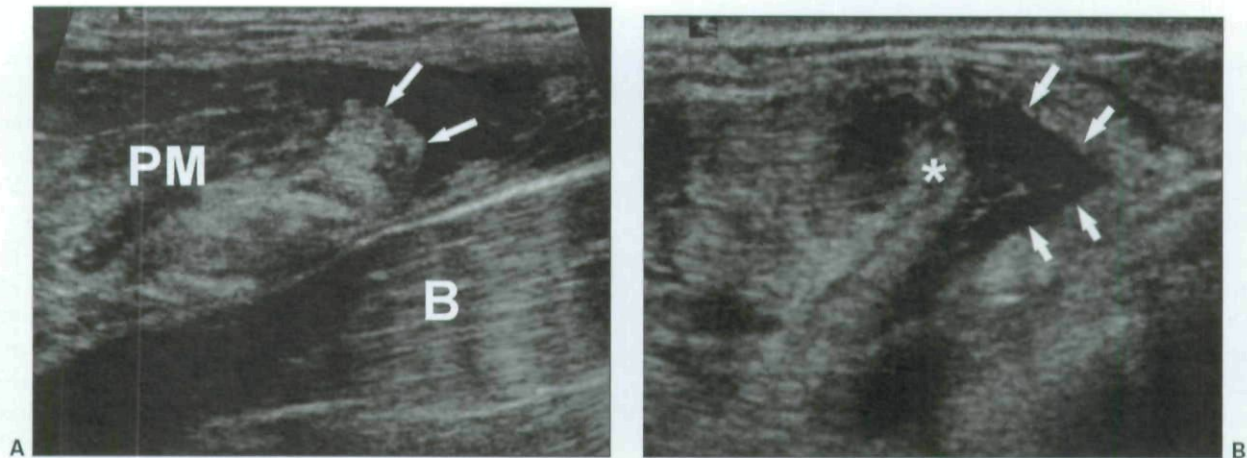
A 19-year-old male hurdler with acute partial tear of the biceps femoris tendon. Longitudinal sonogram shows the retracted end of the biceps femoris central tendon (arrow) surrounded by fluid—giving the “bell clapper” sign—and intact muscle fibers.
